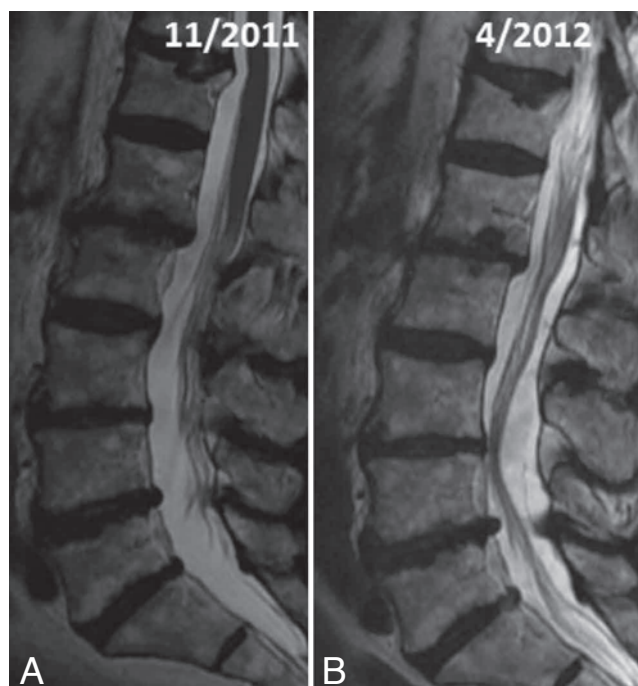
A. Sagittal T2 MRI of the lumbar spine (November 2011): multiple discopathies, no stenosis. B. Sagittal T2 MRI of the lumbar spine (April 2012): lumbar nerve roots pushed anteriorly by a cystic lesion.
